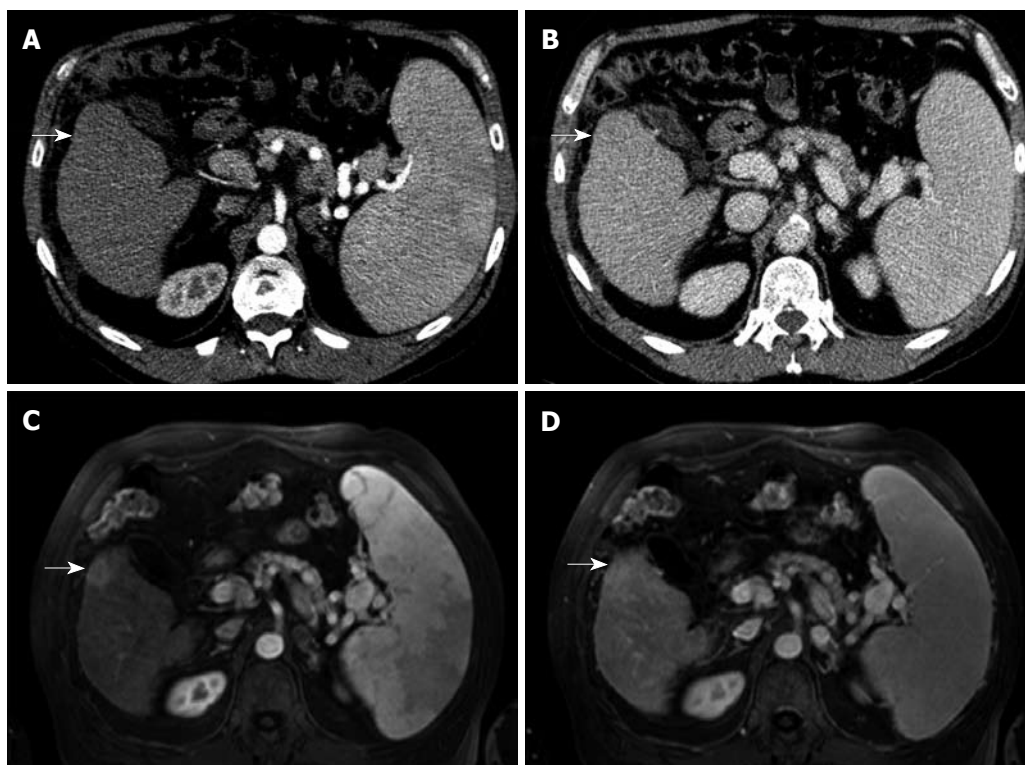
70-year-old man with biopsy-proven HCC. Detection of an additional tumour nodule by MRI, size 19 mm (size category ≤ 20 mm). MDCT demonstrates no hypervascular enhancement in the contrast-enhanced arterial phase (A, arrow) or the portal venous phase (B, arrow). MRI arterial phase depicts a hypervascularized area in the T1w phase (C, arrow) which became isointense in the portal venous phase (D, arrow).
